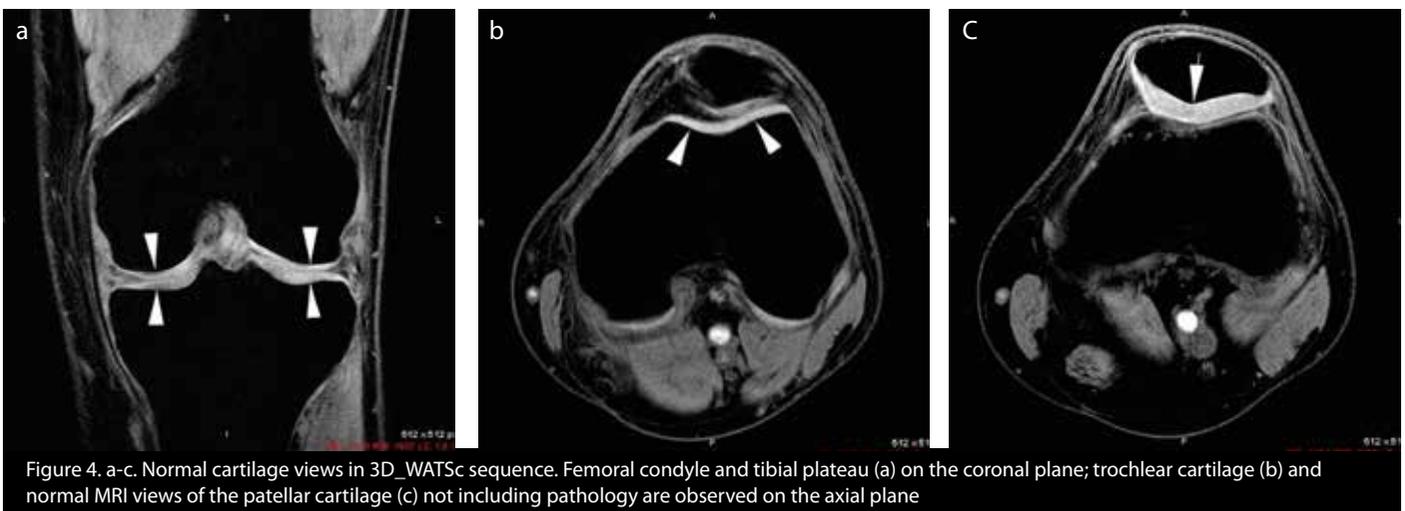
a-c. Normal cartilage views in 3D\_WATSc sequence. Femoral condyle and tibial plateau (a) on the coronal plane; trochlear cartilage (b) and normal MRI views of the patellar cartilage (c) not including pathology are observed on the axial plane
